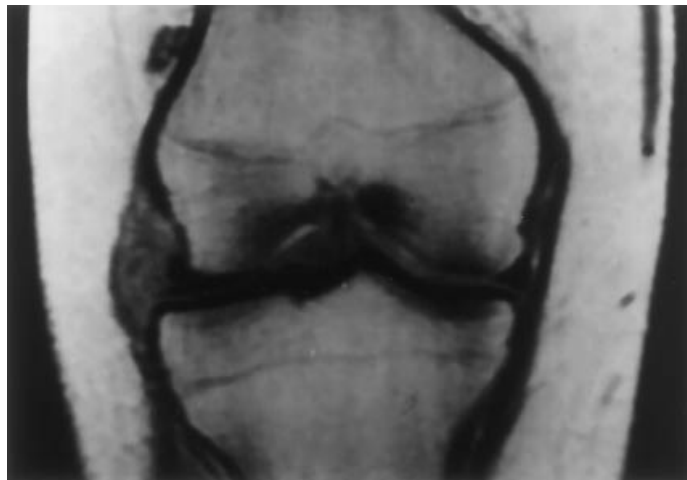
MRI of joints can demonstrate defects in cartilage, ligaments, and bone with greater specificity than possible by other methods including arthroscopy. This image shows a lateral meniscus tear and cyst of the knee (courtesy of D. Rubin, University of Pittsburgh).
